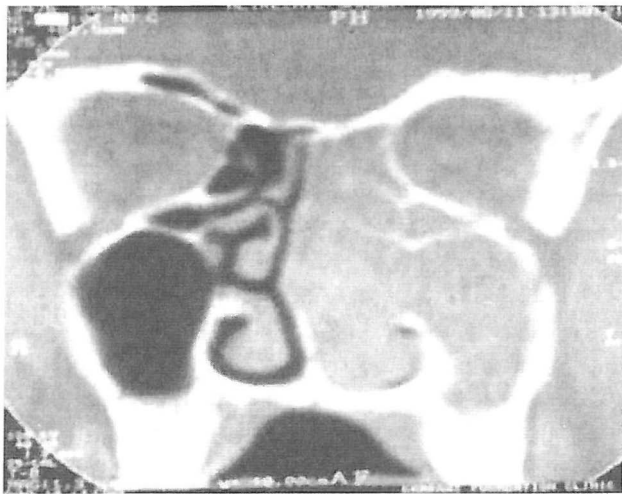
Preoperative coronal CT scan.
